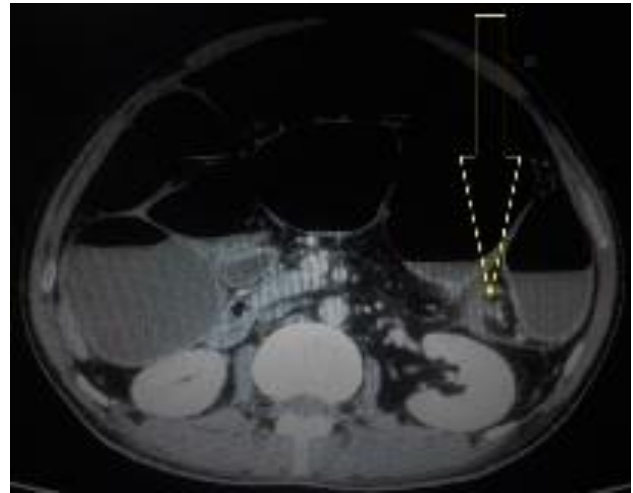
Axial CT abdomen of the patient showing large bowel obstruction and starting of twisting of bowel.
